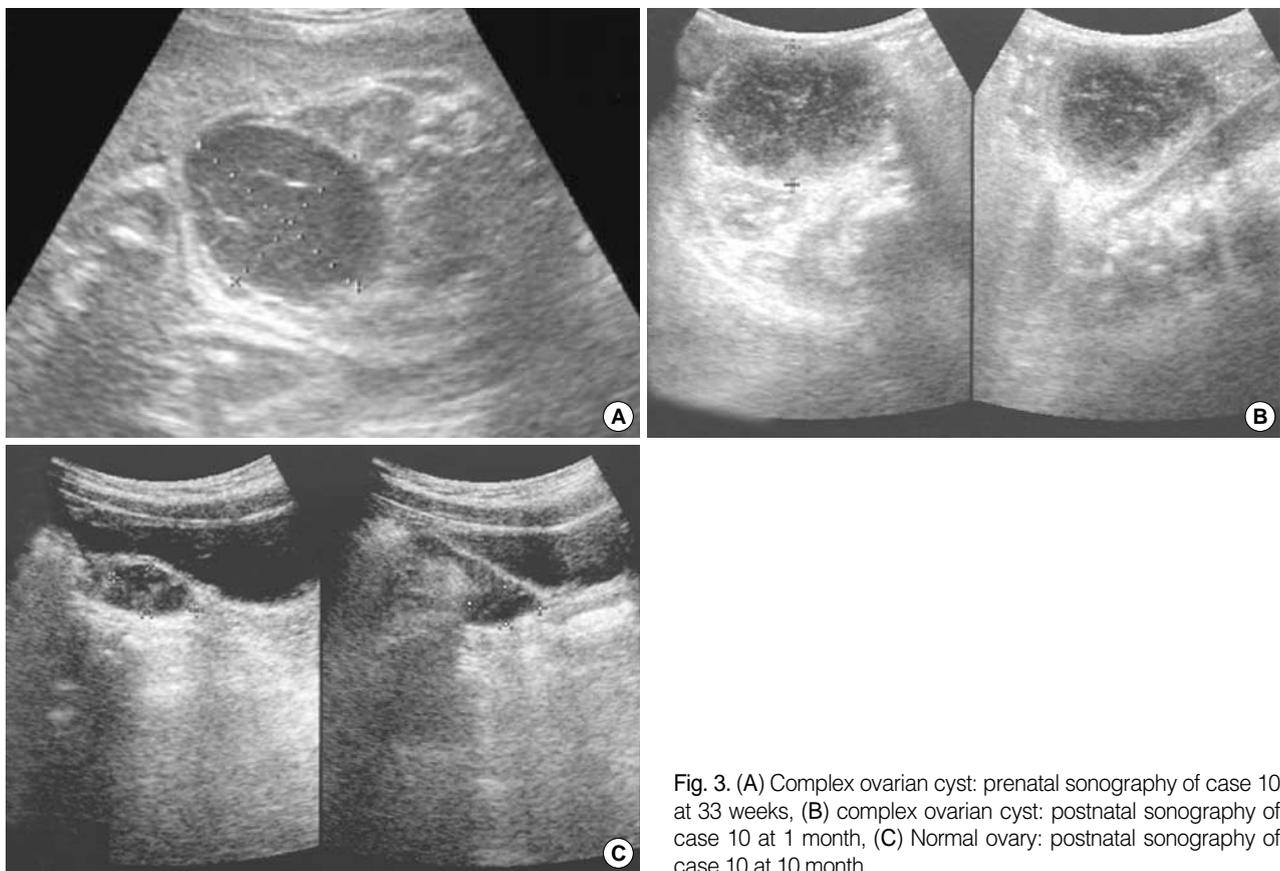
(A) Complex ovarian cyst: prenatal sonography of case 10 at 33 weeks, (B) complex ovarian cyst: postnatal sonography of case 10 at 1 month, (C) Normal ovary: postnatal sonography of case 10 at 10 month.
